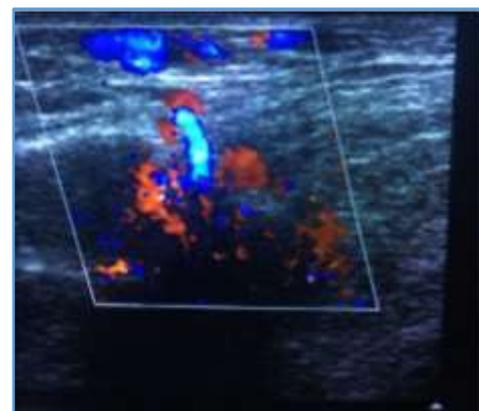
Grey Scale and Colour Doppler Images showing Normal SFJ
